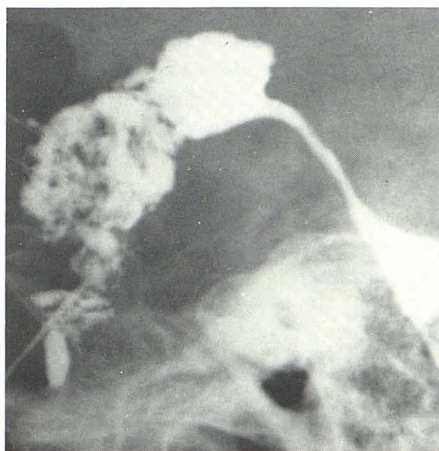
Extravasation of contrast medium into third ventricle in patient with pituitary apoplexy: 54-year-old woman who underwent transfrontal resection of pituitary adenoma 8 years earlier. She was readmitted as emergency with subarachnoid hemorrhage. Investigations, including CT scan, showed hemorrhage into recurrent adenoma, which was seen at surgery to extend into third ventricle.
